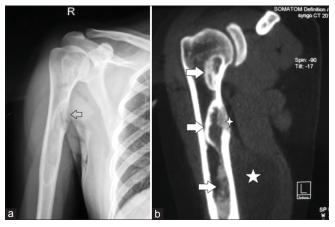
(a) Anteroposterior radiograph of the right humerus showing a diaphyseal lesion with a diffuse "ground-glass" appearance. A bony cortical lesion is also seen arrow (b) Coronal imaging of computed tomography of the humerus showing endosteal scalloping (white arrow) with a solitary hypodense intramuscular mass in the softtissue (white pentagram). Some continuity did exist between fibrous dysplasia of proximal humerus with soft-tissue mass (white star)
